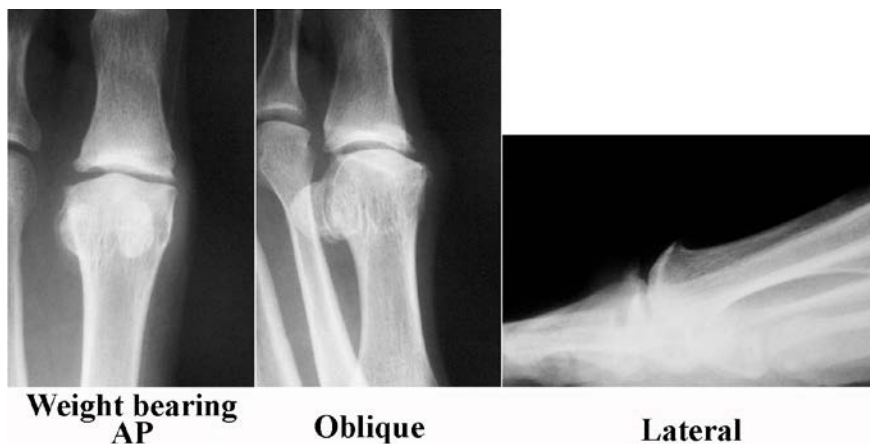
Radiographs demonstrating good agreement case for Grade 2 hallux rigidus.
